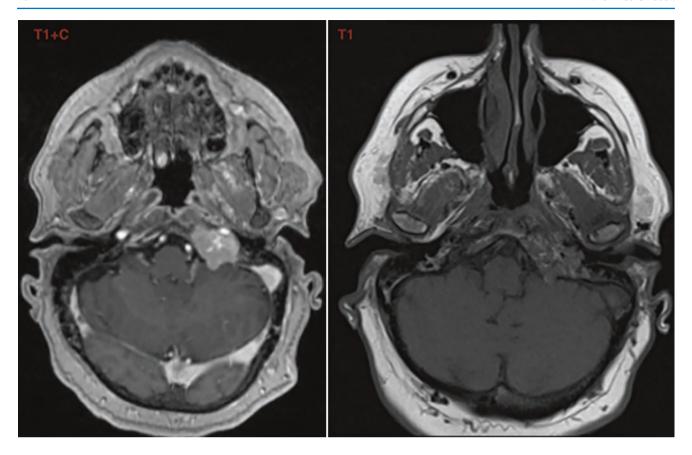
Preoperative MRI, axial
